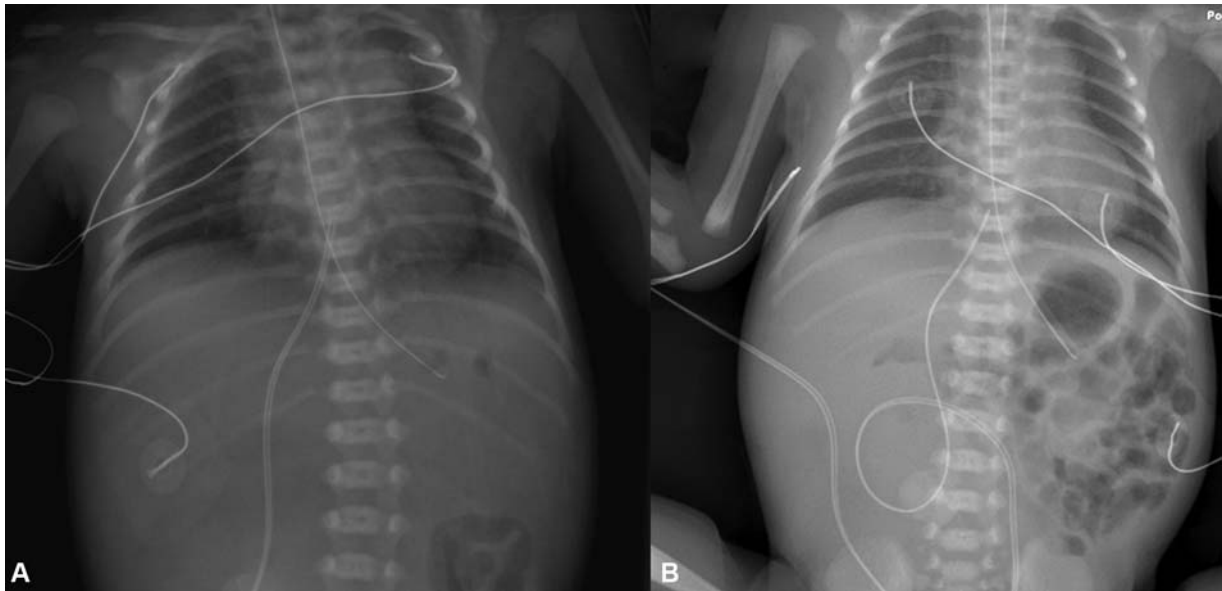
Radiographs of infant. (A) Chest radiograph at presentation. (B) Chest and abdomen on day 2 with abnormal bowel gas pattern.
